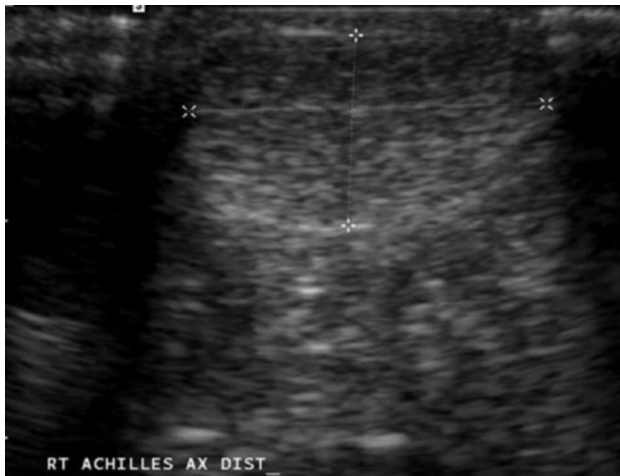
Transverse sonographic image of the right distal Achilles tendon, showing diffuse thickening (cursors).
